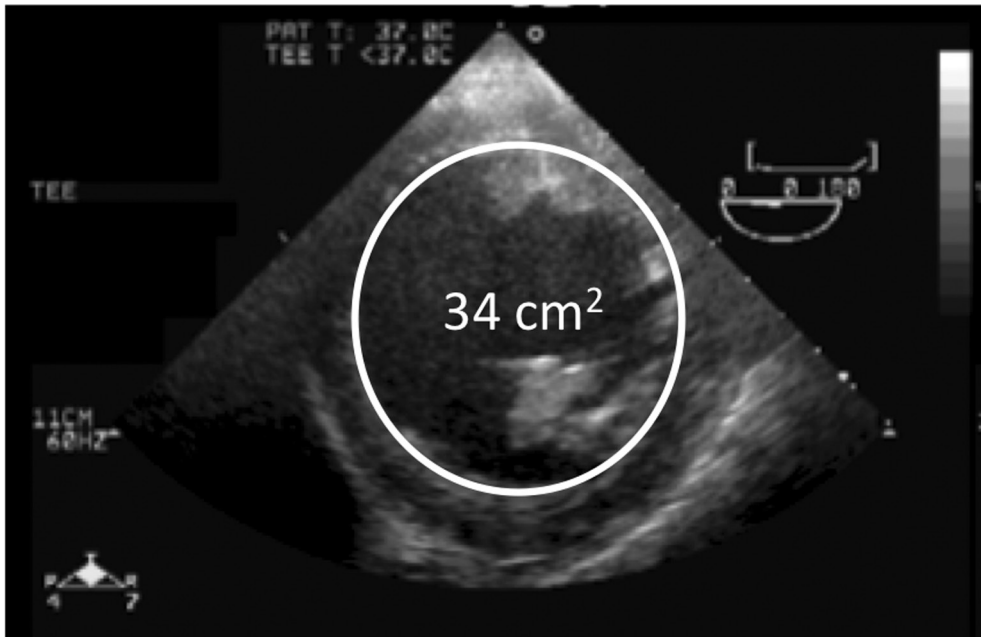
Left ventricular end diastolic area. Large left ventricular end diastolic area obtained with transesophageal echocardiography in a patient with dilated cardiomyopathy. Note that the papillary muscles are included within the surface area
